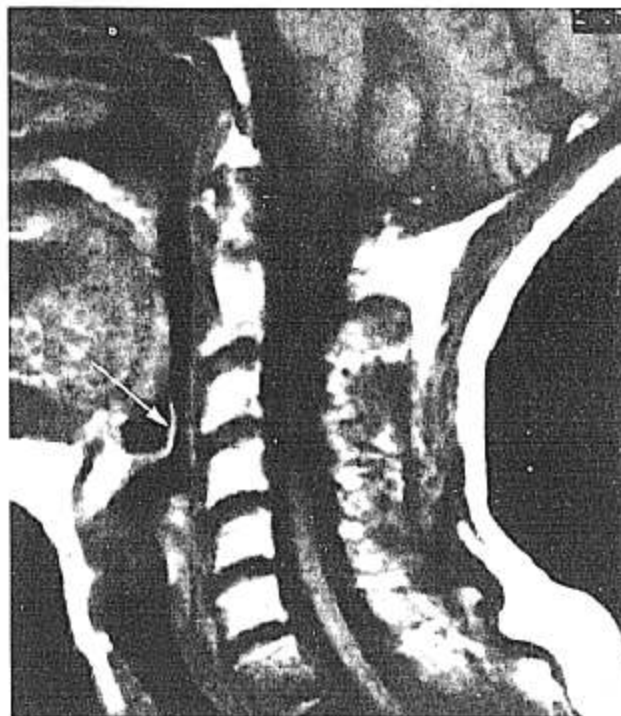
Magnetic resonance image showing elongated epiglottis (arrow). Proximal portion of epiglottis obtains a 90° angle with the base of tongue. Distal portion of epiglottis abuts the posterior pharyngeal wall.
